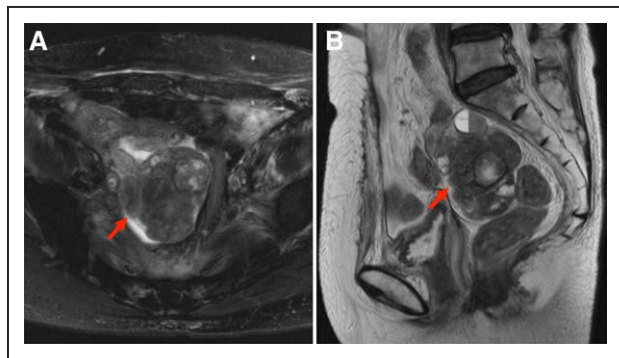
Pelvic magnetic resonance image of the ovarian carcinoid. An axial fat-saturated T2-weighted image (A) and a sagittal T2-weighted image (B) of the ovarian carcinoid. Arrow indicates the ovarian carcinoid.
